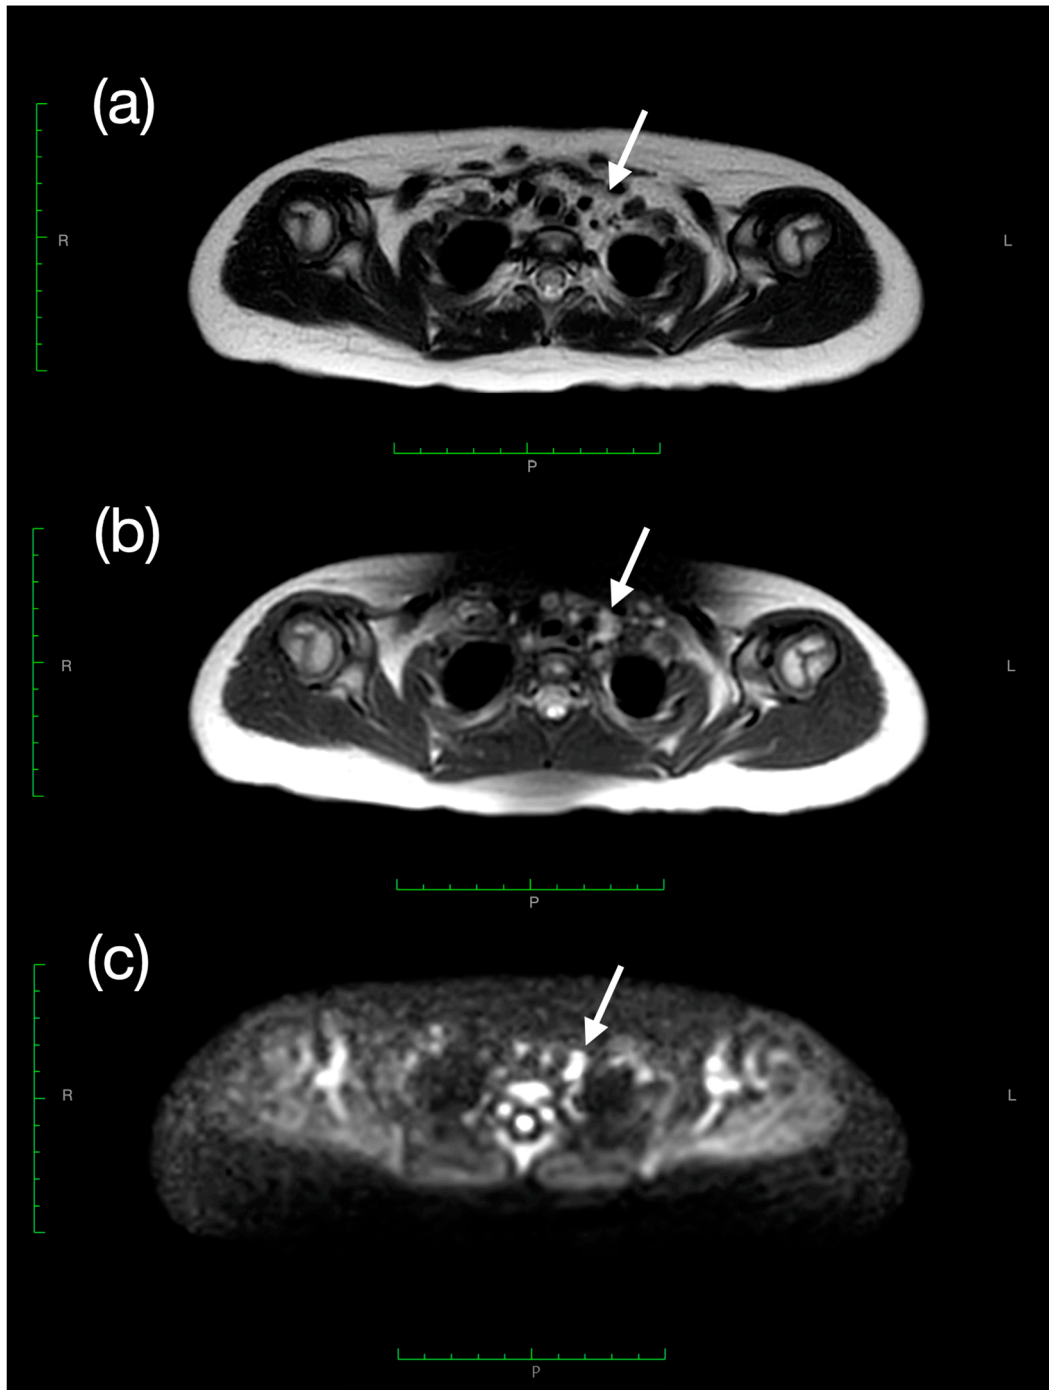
Axial magnetic resonance imaging of the neck (slice thickness 3 mm; TR 4691, TE 100): (a) Axial T2-weighted sequence showing a mildly hyperintense solid tissue within the left jugular region (arrow). (b) Axial SPAIR sequence confirming the same finding with fat suppression (arrow). (c) Axial DWIBS sequence demonstrating restricted diffusion in the same 11 mm jugular lesion, corresponding to the ultrasound finding and compatible with a lymph node (arrow).
